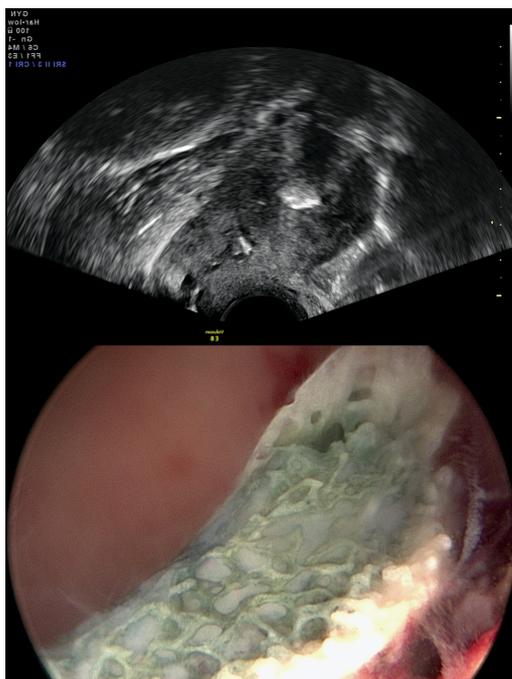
Endovaginal ultrasound – hyperechogenic image in the uterine cavity (mimics an IUD) and hysteroscopy image – coral-like bony fragments inside of the uterine cavity.
